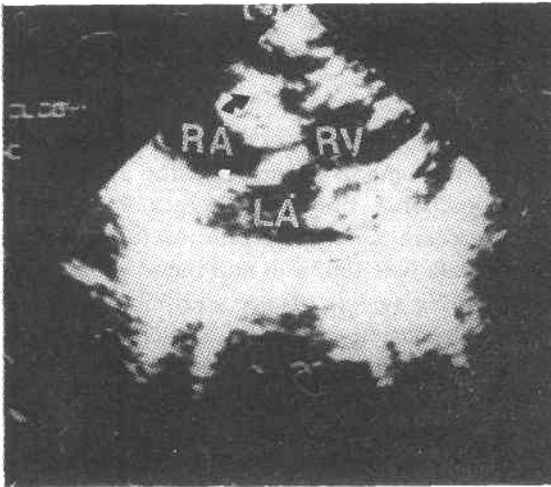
Echocardiogram (subcostal oblique cut) showing large vegetation in right atrium attached to the tricuspid valve (arrow). RA- right atrium; LA- left atrium; RV- right ventricle
